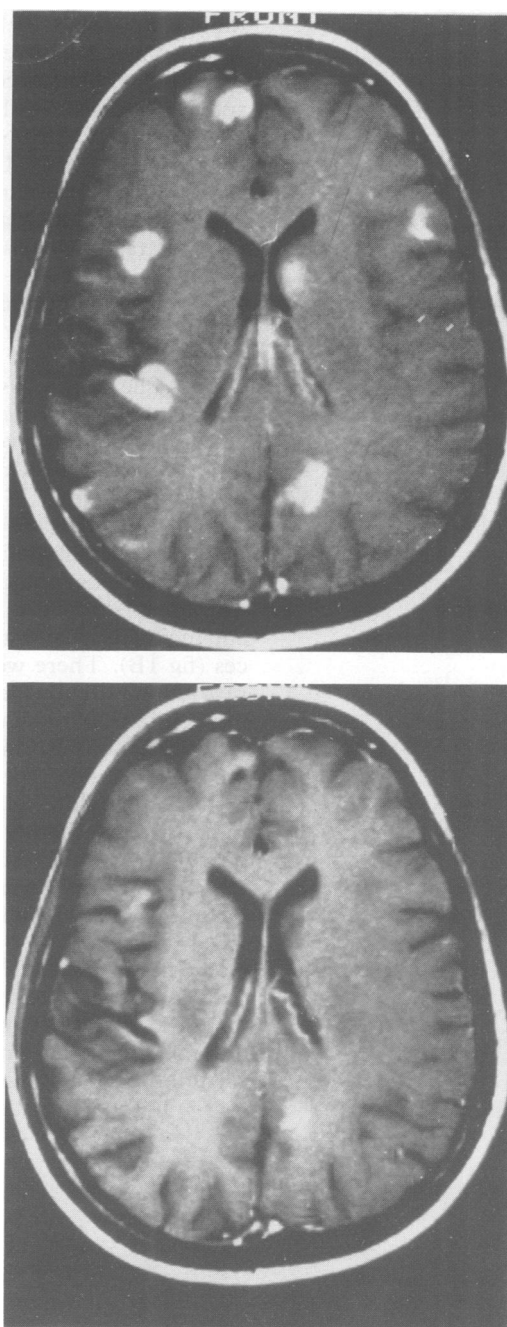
Figure Cranial MRI, gadolinium-enhanced T₁-weighted sequences TE 600 ms, TR 15 ms; A) Before therapy and B) after therapy.
